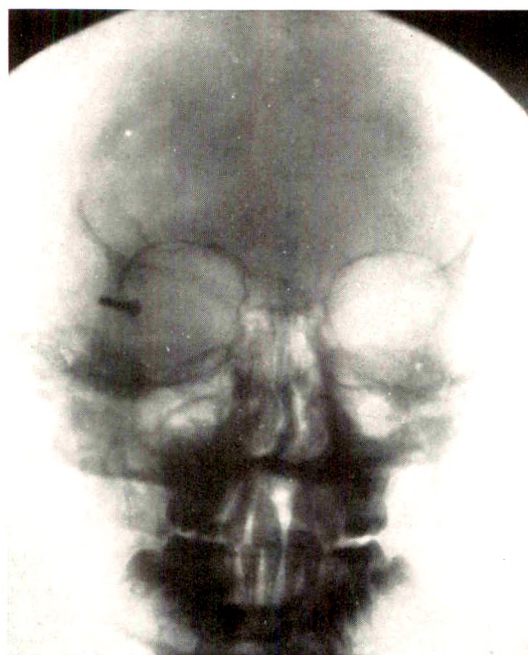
Frontal view of nail. This was successfully removed through a small trephine opening on the double plane roentgenoscopic table.
